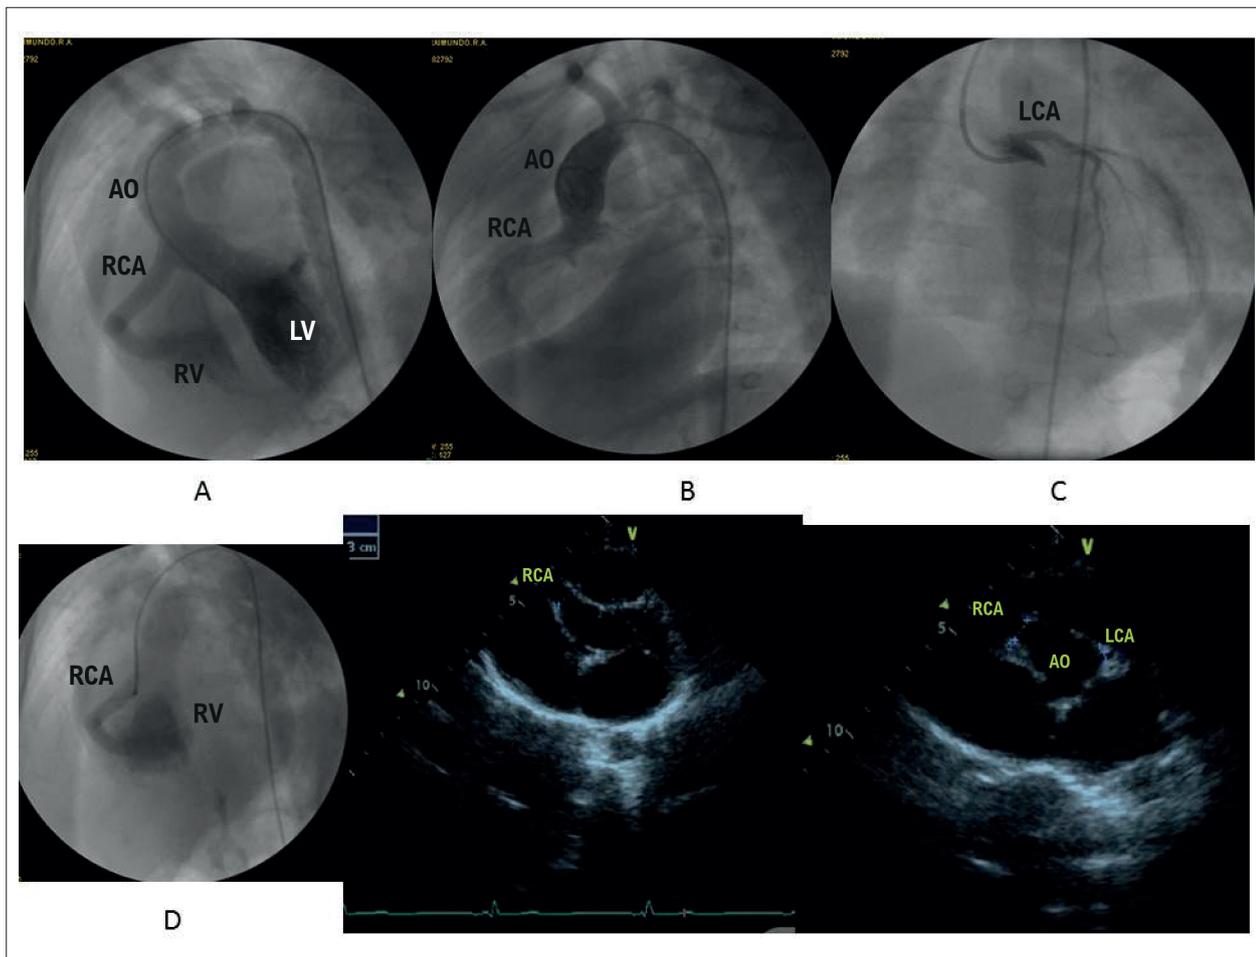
Angiography highlights the dilated right coronary artery in connection with the right ventricular cavity in A, B and D and the normal-sized left coronary artery in C, in the period prior to cardiac surgery. Recent cross-sectional echocardiogram images also show the large dilation of the right coronary artery in the emergence of the aorta. Ao: aorta; RCA: right coronary artery; LCA: left coronary artery; RV: right ventricle; LV: left ventricle.
